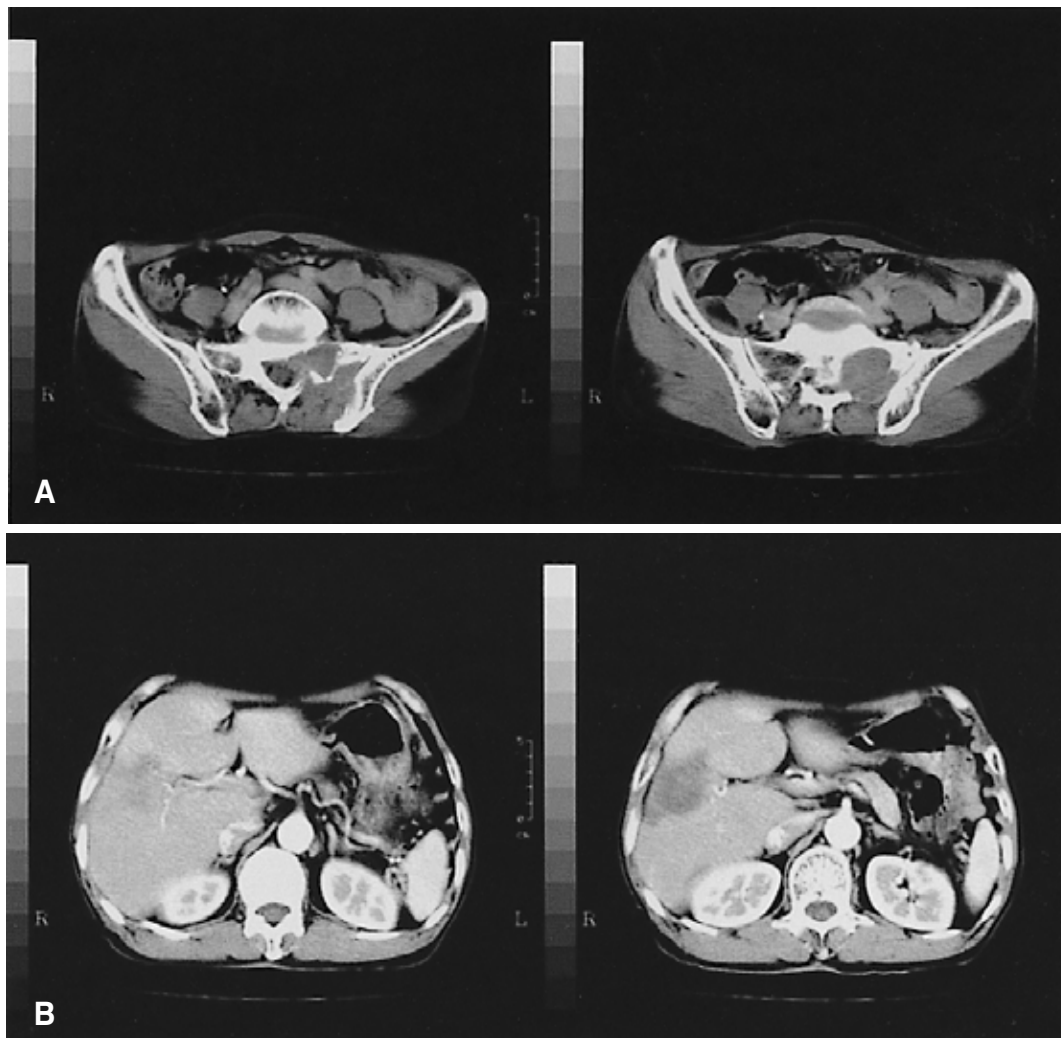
(A) Computed tomography showing a metastatic mass invading the left sacrum. (B) Computed tomography showing decreased hepatic mass compared to initial scan.
